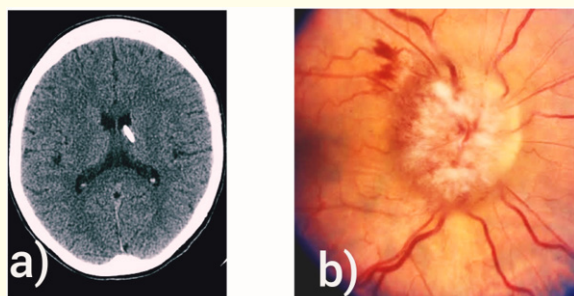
a) Computerised tomography (CT) of head suggestive of normal looking ventricles with VP shunt in situ with no ventriculomegaly or flattened sulci or enlarged subarachnoid space suggestive of raised ICP.
